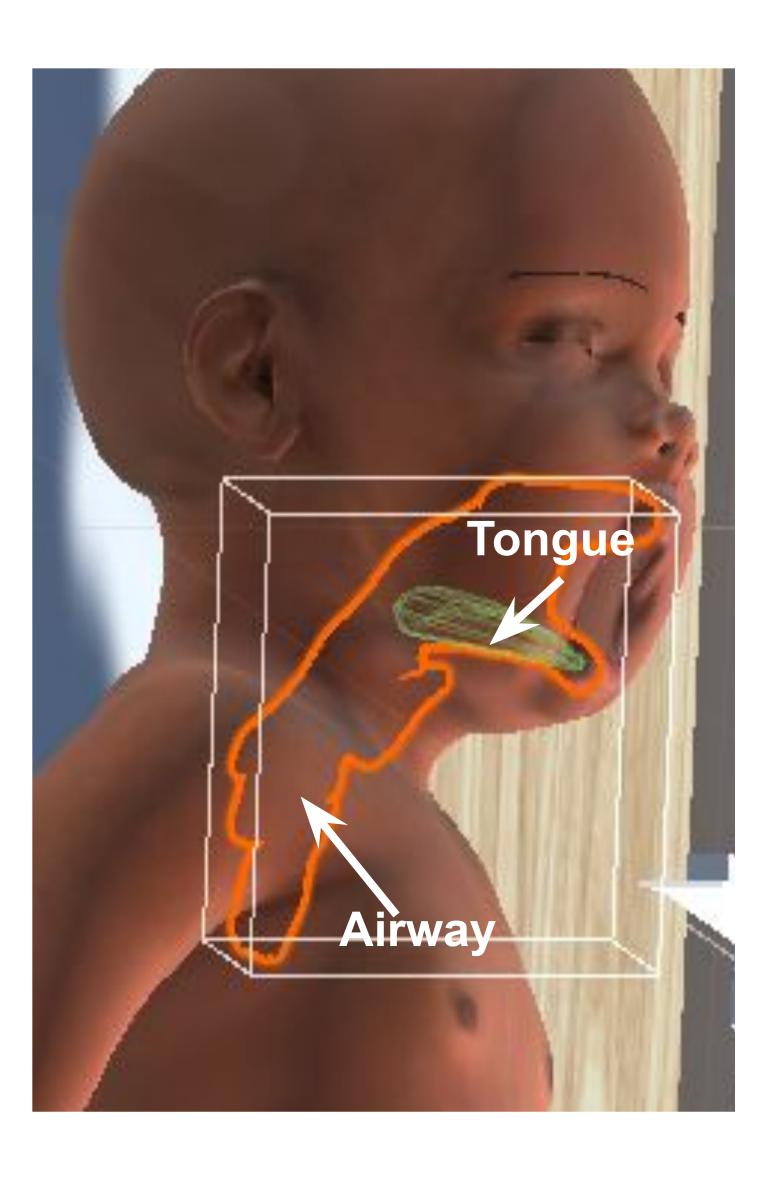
(Below): A human infant CT scan was reconstructed and rendered in Blender to create an anatomically accurate physical model of the inner anatomy of the throat
